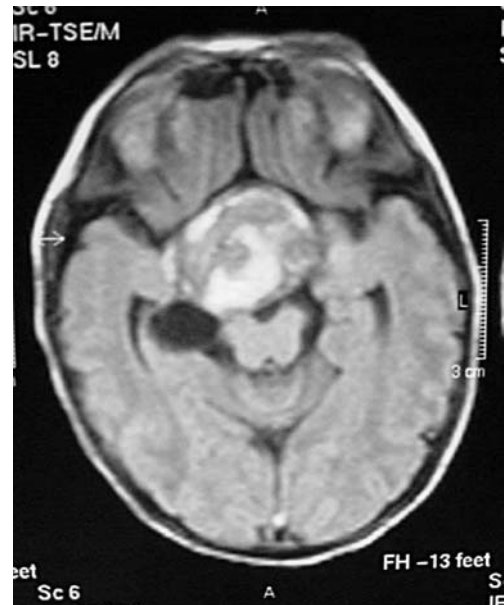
Postnatal MRI at 40 days: axial T2-weighted image showing slight progression of the lesion compared with the previous MRI, with hypersignal and hyposignal and a posterior cystic component
